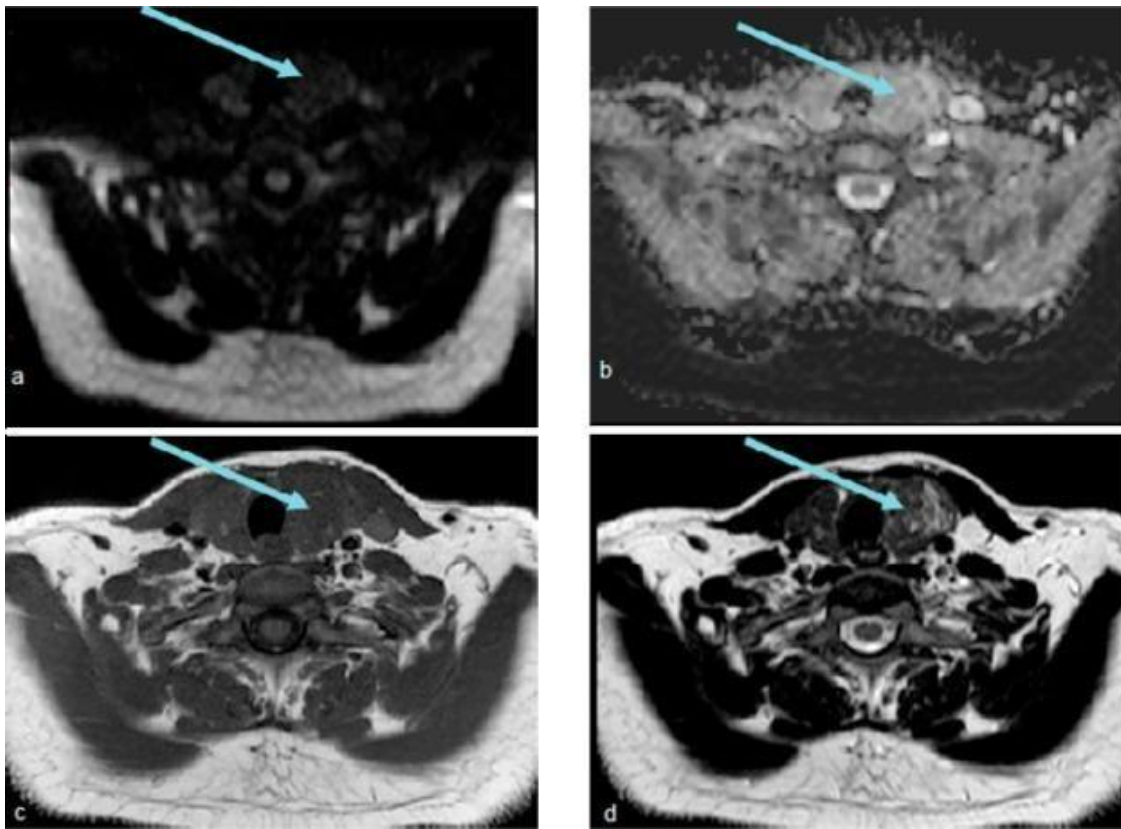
(a–d) MRI images (a) Axial DWI (b) Axial ADC map (c) Axial T1WI (d) Axial T2WI. These images show left thyroid nodules (arrows) demonstrating intermediate in homogenous T1 and T2 signal intensity with facilitated diffusion seen as low signal intensity in the DWI and intermediate signal intensity in the ADC map with a mean ADC value reading $1.5 \times 10^{-3} \text{ mm}^2/\text{s}$.⁵⁹
